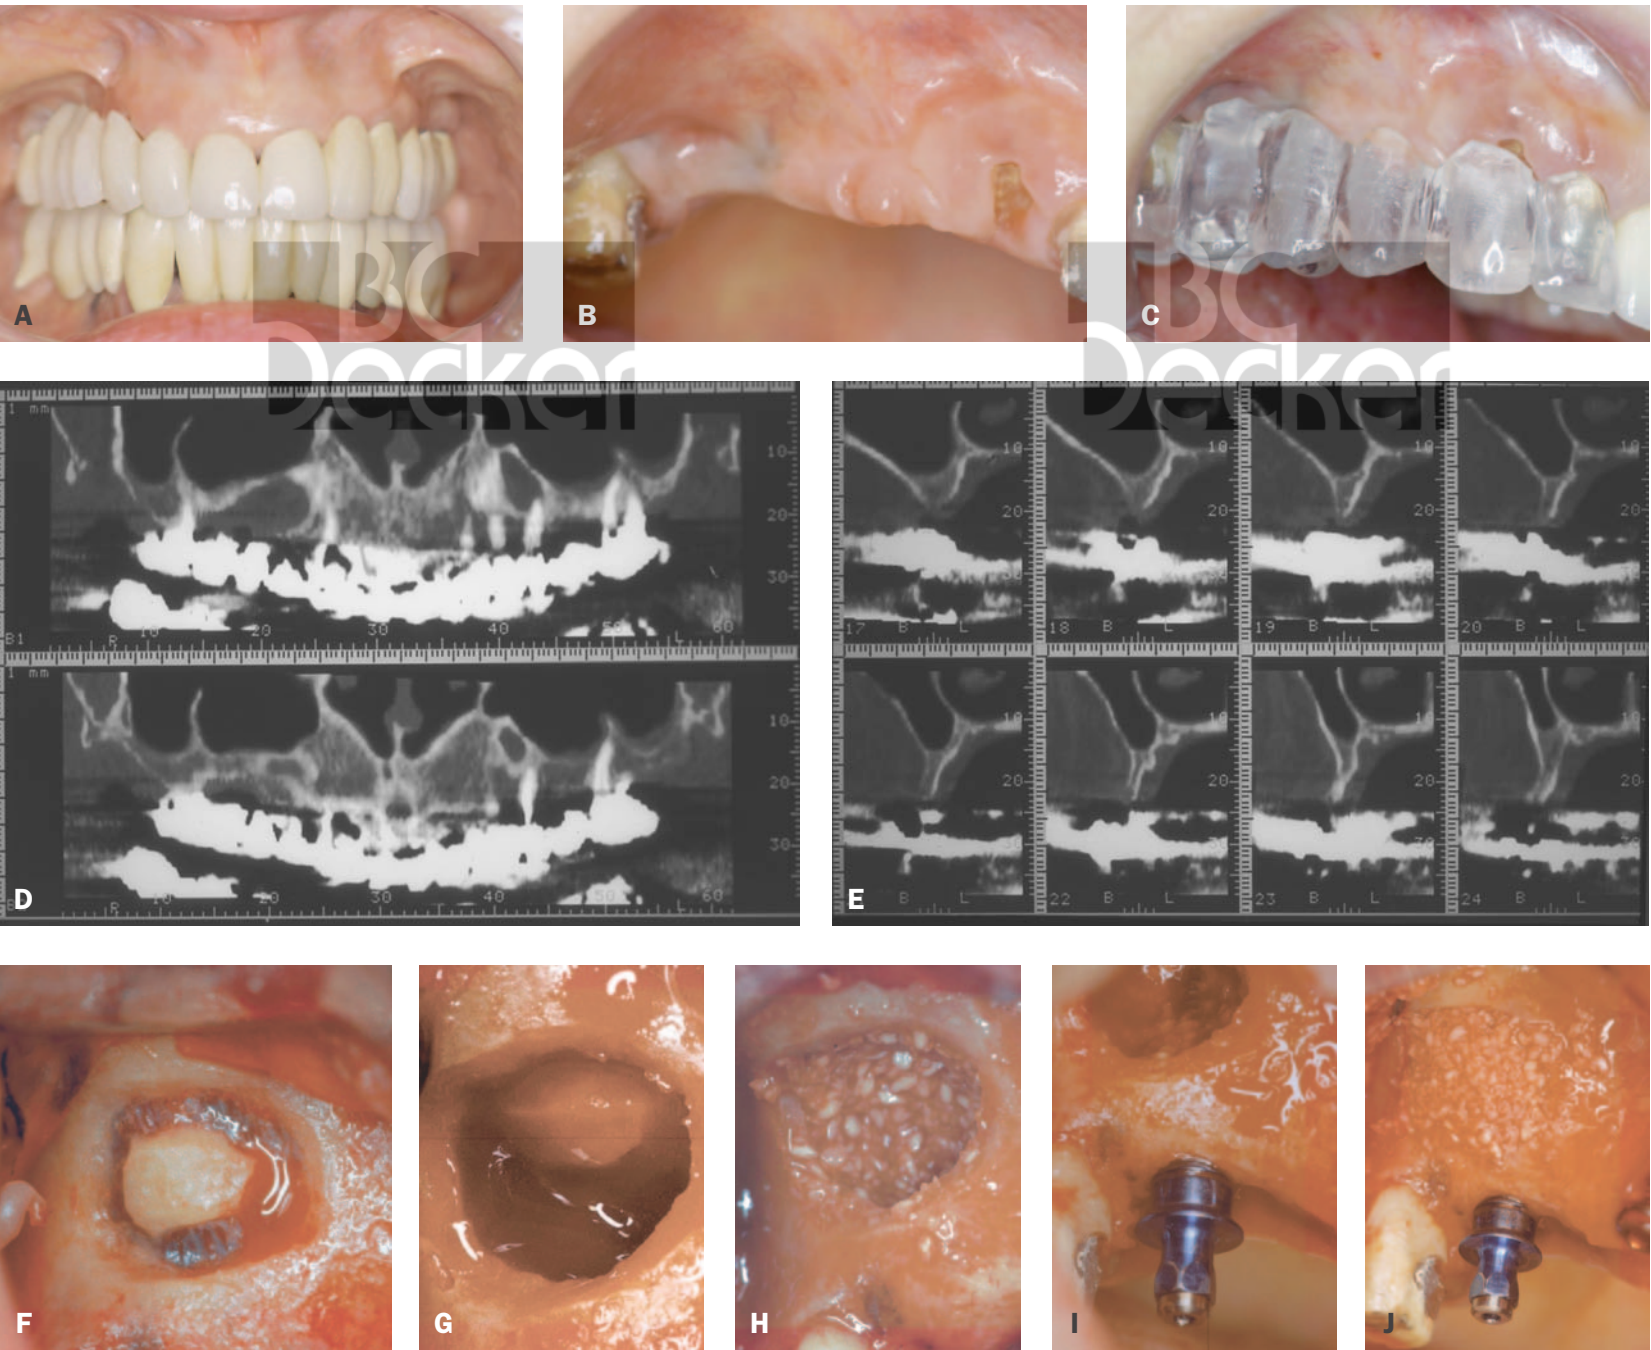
Guided tissue regeneration. Immediate loading. *A*, Preoperative view with a temporary bridge in position. *B*, Preoperative view of the edentulous ridge. *C*, Surgical stent in place duplicates final temporary bridge. *D*, Panorex radiograph showing a large bony septa. *E*, Cross-sectional views showing a thin edentulous ridge. *F*, Sinus window outlined. Note blue hue of sinus. *G*, Window reflected. Sinus lift complete. *H*, Graft material (FDBA) placed anteriorly, medially, and occlusally prior to implant placement. *I*, Implant placement into sinus. *J*, Sinus fill complete with FDBA.
